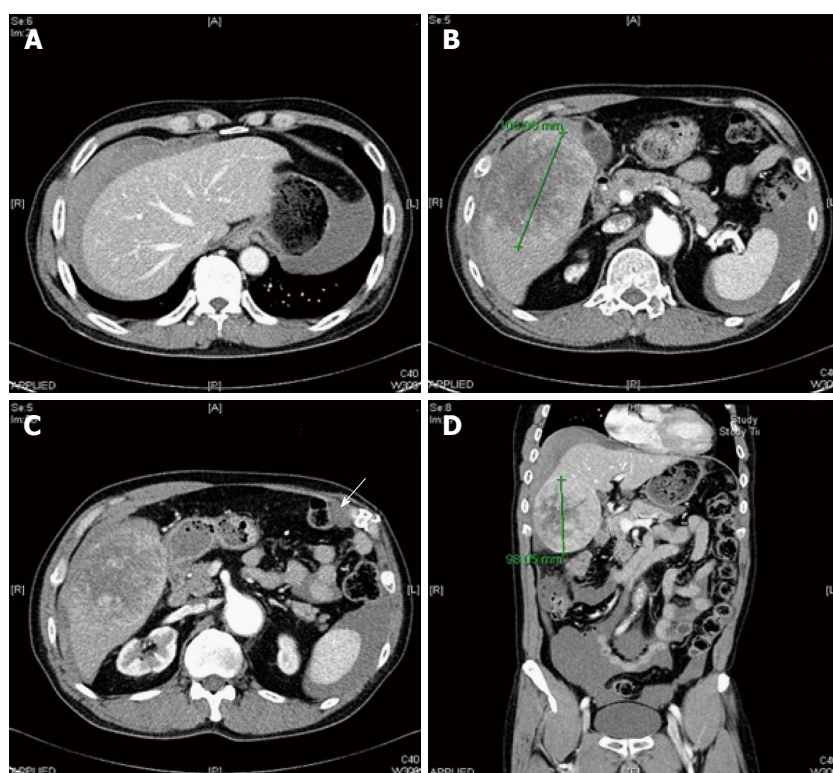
Enhanced computed tomography images. A: Large hemoperitoneum is seen around the liver; B: A 10-cm encapsulated mass is seen in S5 and S8 of the liver, and hemoperitoneum is seen around the spleen; C: A 2.3-cm nodular lesion is seen in the right upper quadrant of the abdomen adjacent to the left transverse abdominal muscle (white arrow); D: Coronal view of the large hemoperitoneum with a liver mass.
